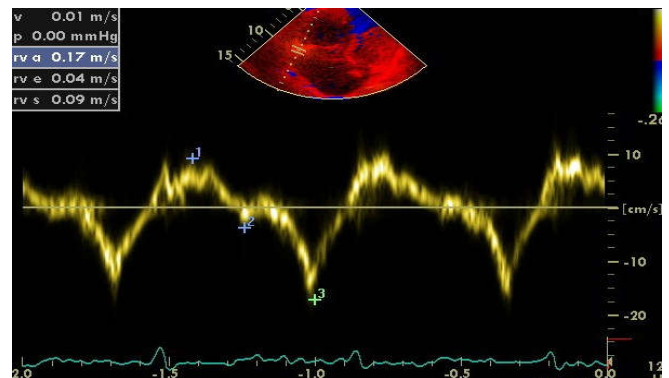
Measure of RV tissue doppler(RVs, RVa', RVe')
